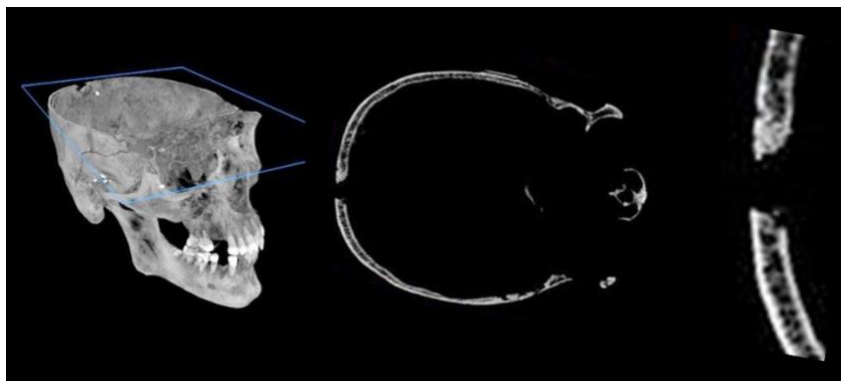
CT-derived transverse cross-section of the cone crack in Case 3 showing angled fracture margins and lack of cortical lining of the perforation (since this section is superior to the lambdoidal suture)
